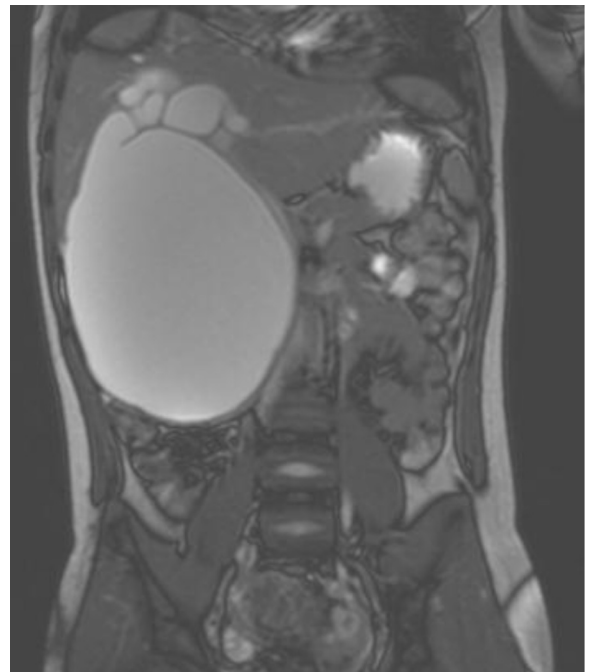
Magnetic resonance images showing a massive choledochal cyst, dilated cystic and common bile ducts, and mildly dilated intrahepatic ducts.
